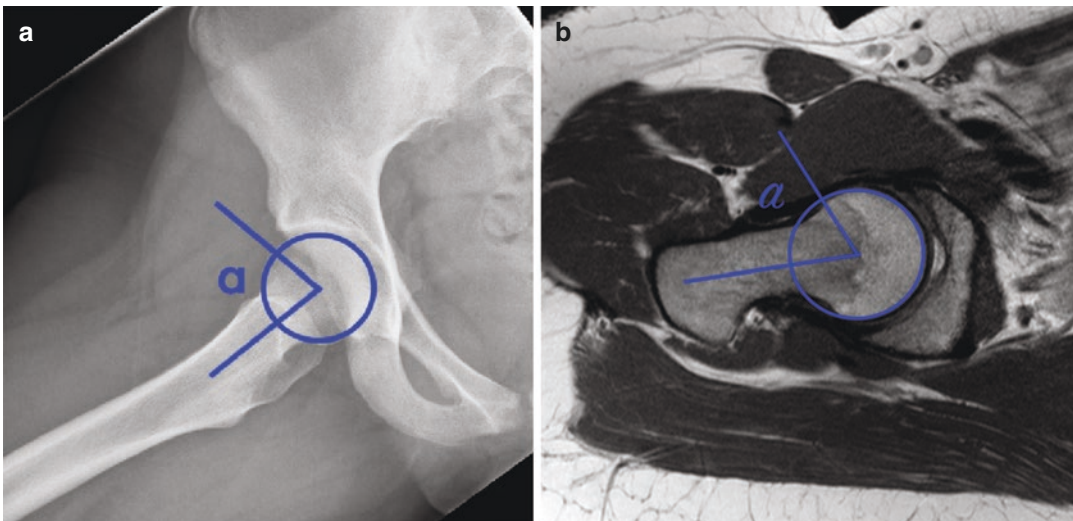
(a) Dunn lateral radiograph is shown for the same patient with mixed type FAI with the alpha angle drawn. A circle is outlined over the femoral head, using the posterior aspect of the head as the reference to place the circle. The angle is drawn with the vertex at the center
